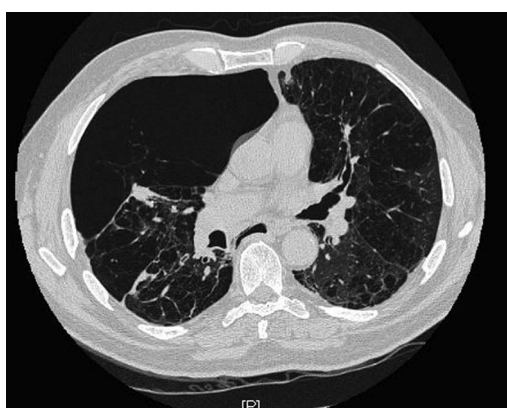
CT scan showing bilateral emphysema with a giant bulla in the right hemithorax.
